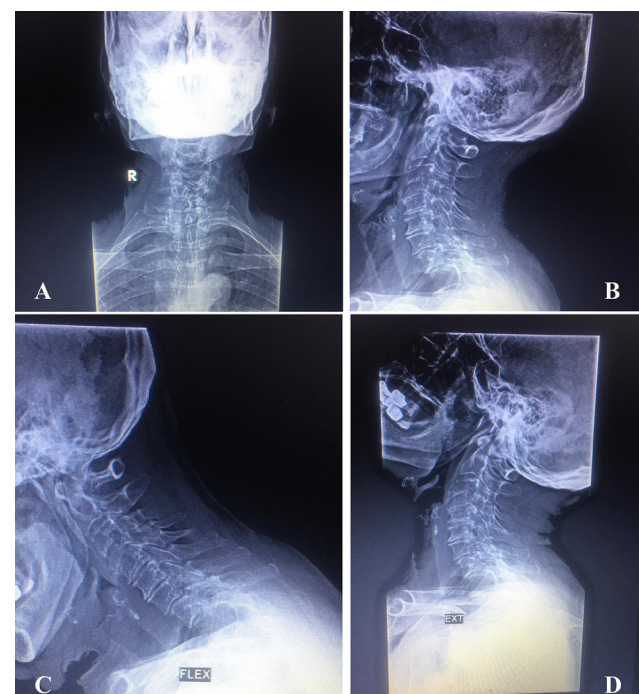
Plain x-ray (AP, lateral and dynamic: flexion and extension views) of a case of spondylo-degenerative cervical spine changes
